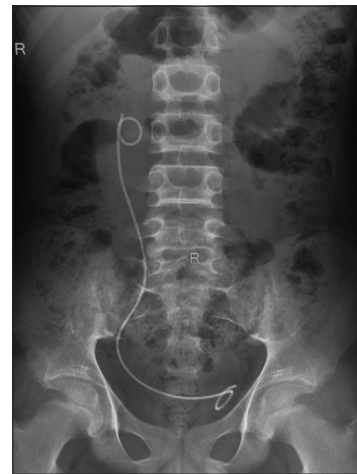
Post-operative kidney, ureter and bladder X-ray with DJ stent
